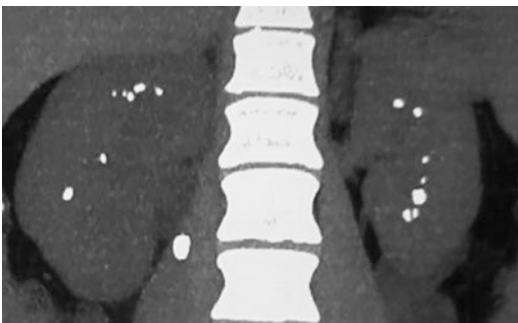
CT image of the kidney with multiple calyceal calculi
